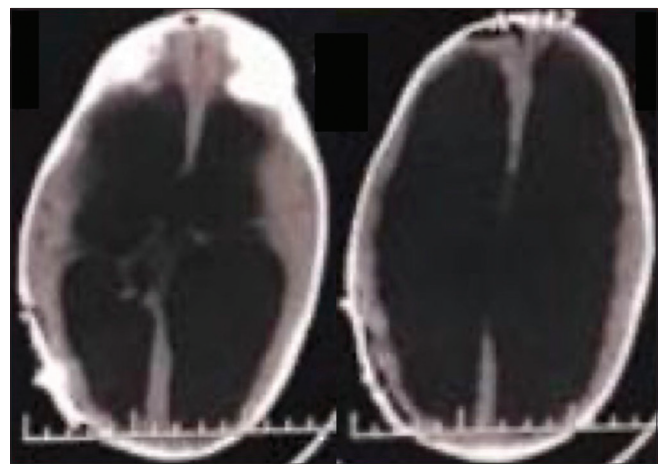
Computed tomography head showing evacuation of the previously seen epidural hematoma.
